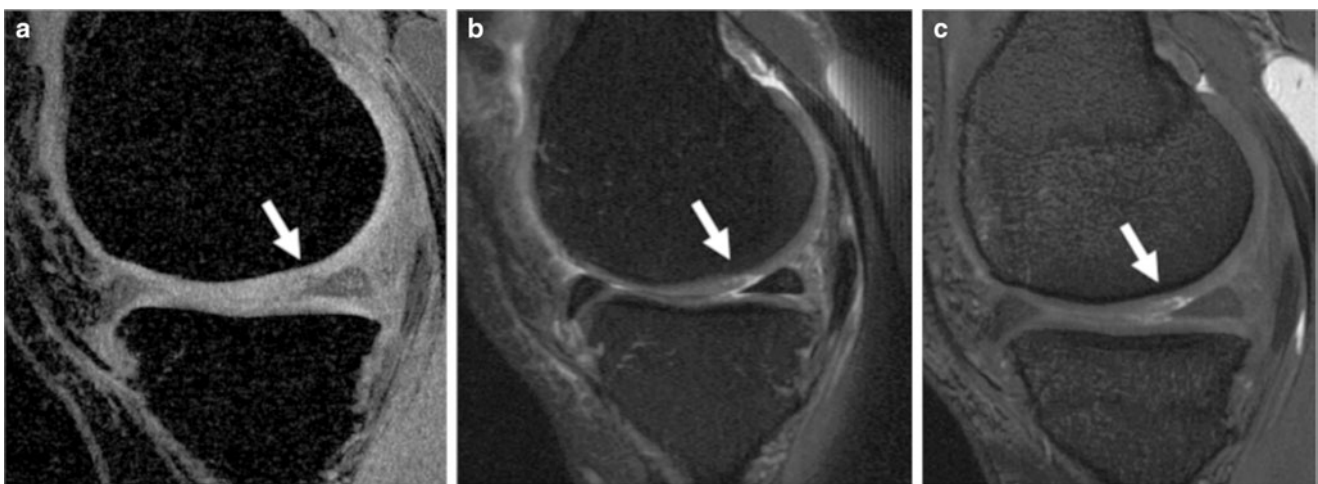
Sagittal MR images of the knee obtained in a middle-aged runner using (a) a fat-suppressed SPGR (21/12.5 ms, flip angle: 15°), (b) an IM-weighted FSE (4,300/51 ms) and (c) a non-fat-suppressed fluid-sensitive fast imaging employing steady-state acquisition
